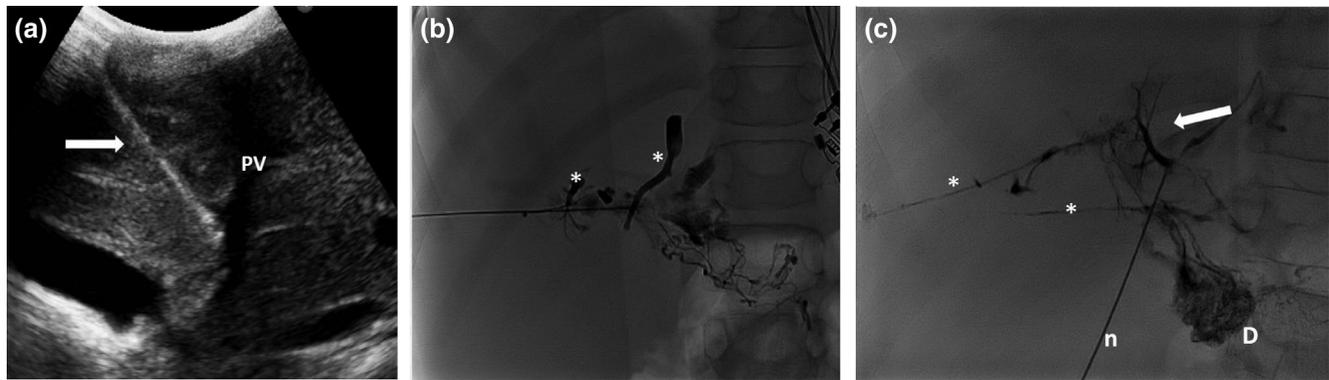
Periportal NBCA embolization of dilated hepatoduodenal lymphatic vessels for PLE. (a) Transhepatic puncture under ultrasound guidance (patient 1). Needle (arrow) can be seen in close approximation to PV. (b) Right-sided Lipiodol–NBCA lymphatic lacteals filled and occluded in patient 2. (c) Small hepatic veins embolized (*). Patient 5: glue being injected into dilated hepatoduodenal lymph vessels. The glue entered a small branch of the portal vein (white arrow). Tract of right-sided periportal punctures visible with glue in transhepatic tract (*) to seal off tract and prevent hemorrhage into ascites. Filling and occlusion of lacteals with duodenal spillage (D) can be observed. Needle (n) still in periportal lymphatics. NBCA, *n*-butyl-2-cyanoacrylate; PV, portal vein
